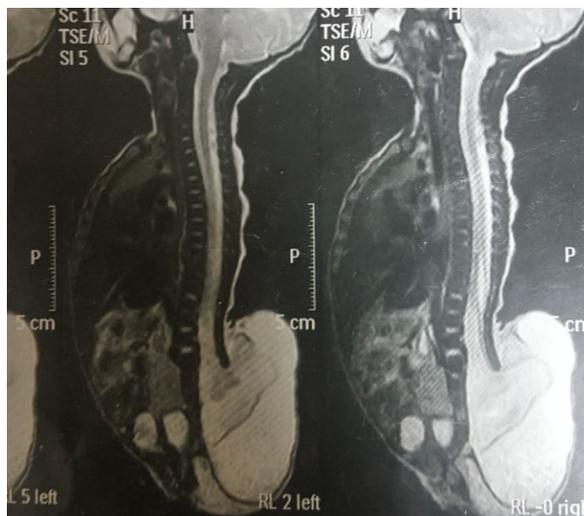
MRI whole spine (sagittal T2) showing large myelomeningocele
